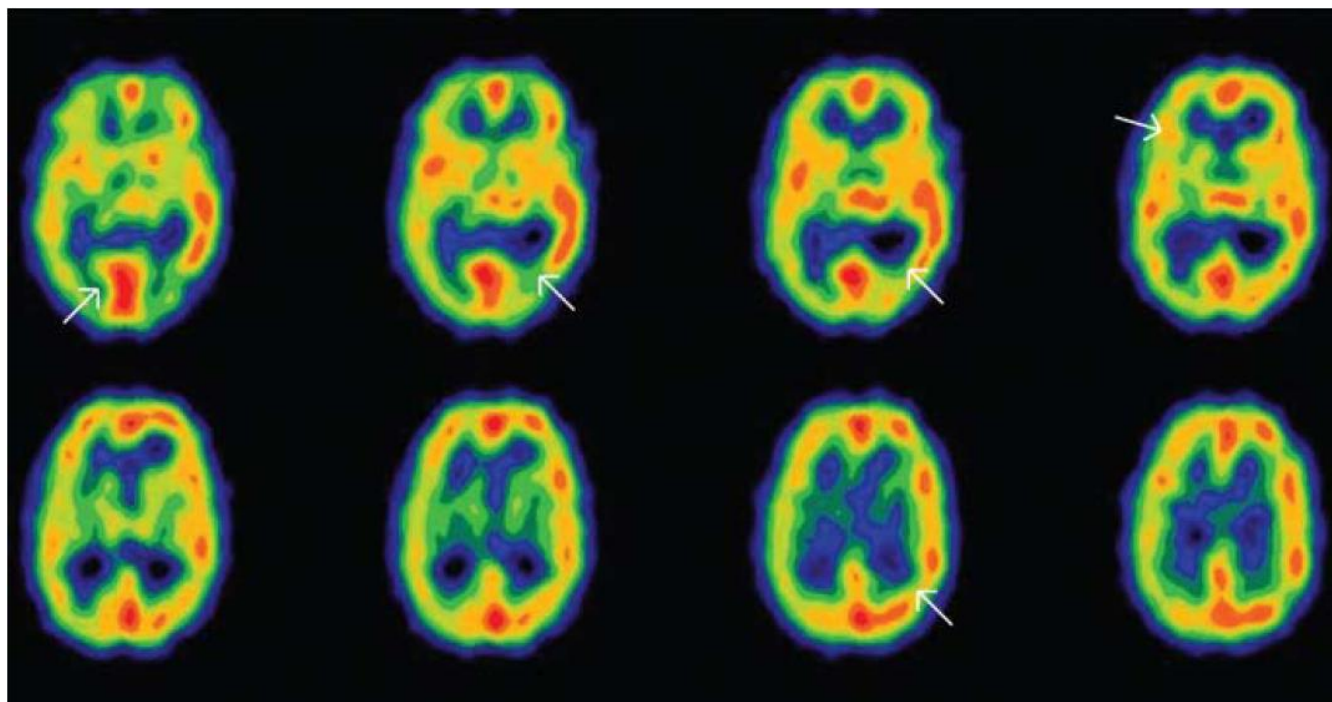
HIV Associated Dementia. 99m-Tc- ethylcysteinate dimer brain perfusion SPECT; temporally reoriented transaxial cut. Hypoperfusion areas are seen in the frontal, parietal, temporal and occipital cortexes (arrows).
